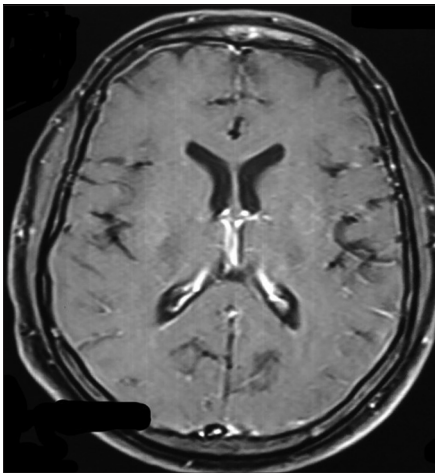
MRI Brain grossly normal features
